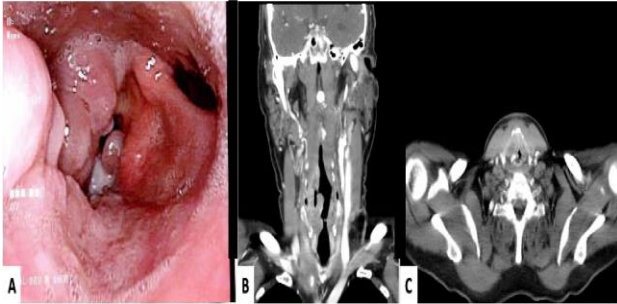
(A) Flexible laryngoscopy showing a bulky, right-sided transglottic laryngeal mass with airway compromise; (B and C) CT-scan images showing laryngeal mass with airway compromise and extensive laryngeal destruction.
